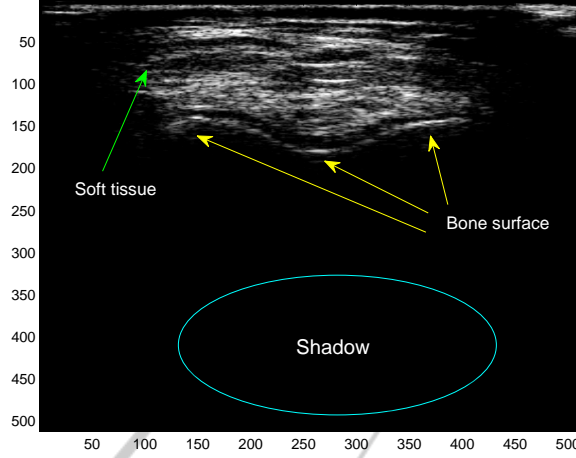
An ultrasound image of the femoral condyles. We can easily distinguish the *bone interface* and the *shadow* that represents the non-echo zone under the bone.
